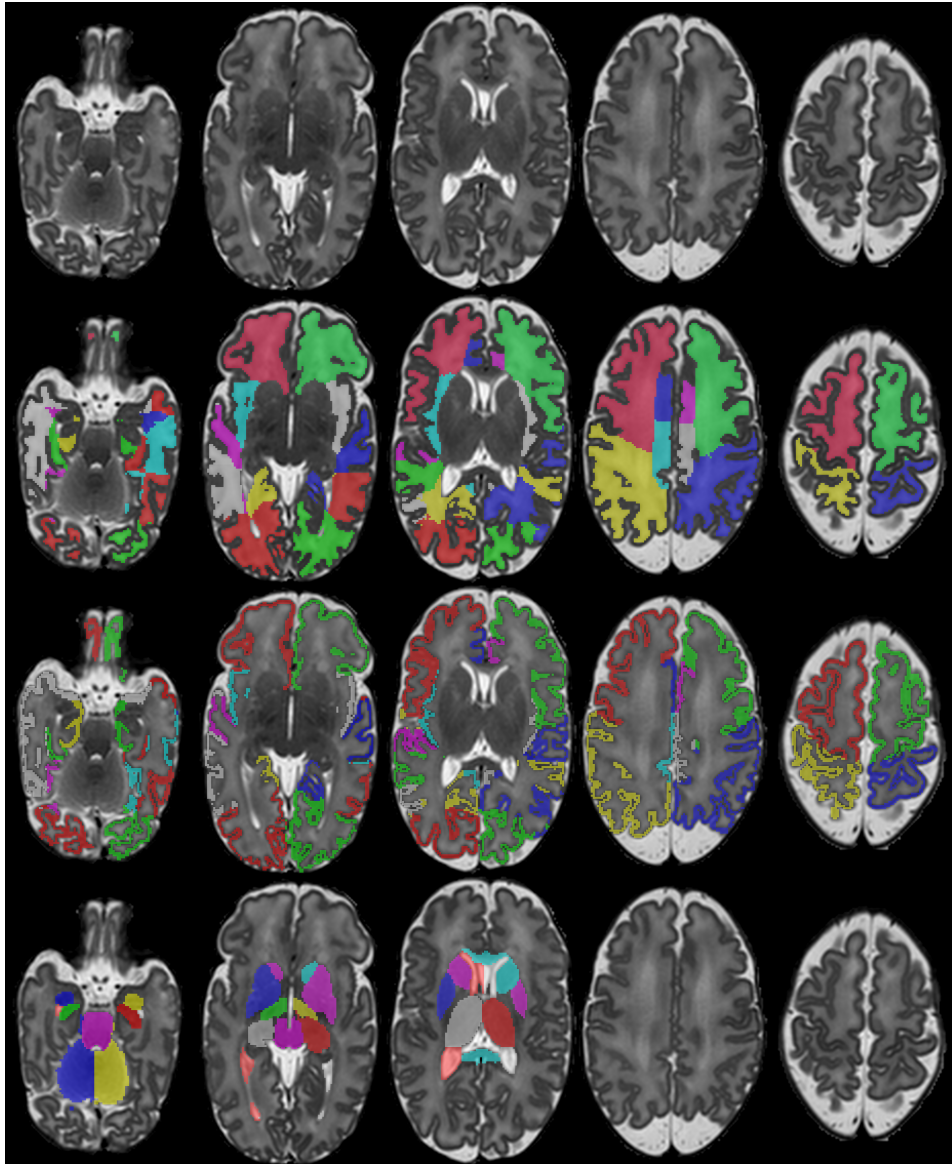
Example structural segmentation of a neonatal MRI acquired at 36 weeks PMA with the method proposed in this thesis (second row: WM labels, third row: CGM labels, fourth row: subcortical GM labels and ventricles).
